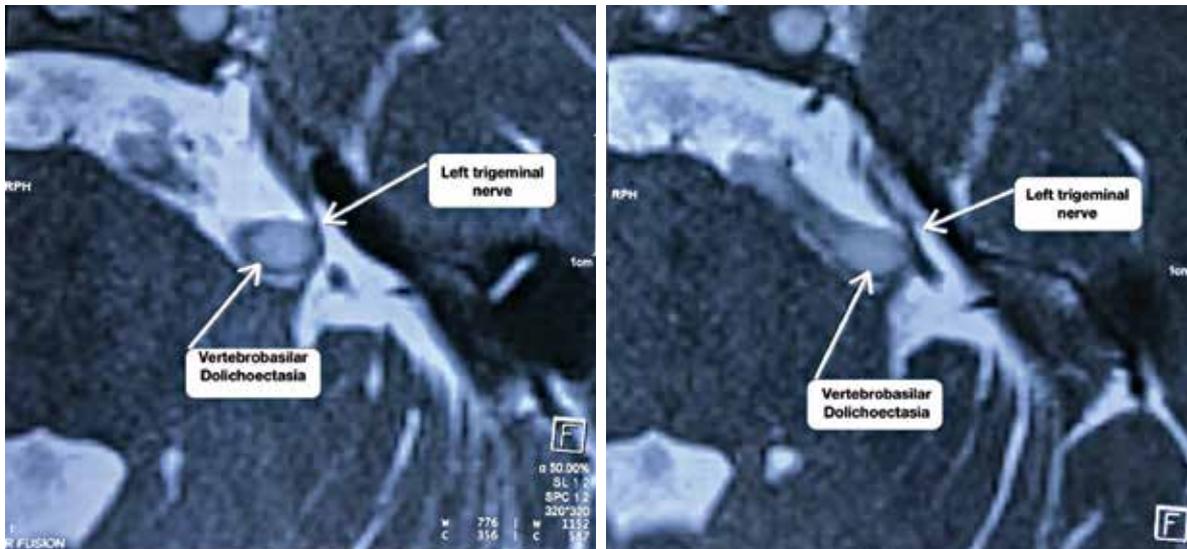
Brain magnetic resonance imaging with gadolinium contrast revealed a neurovascular conflict between vertebral basilar dolichoectasia and left trigeminal nerve on three-dimensional constructive interference in steady state (3D CISS)
